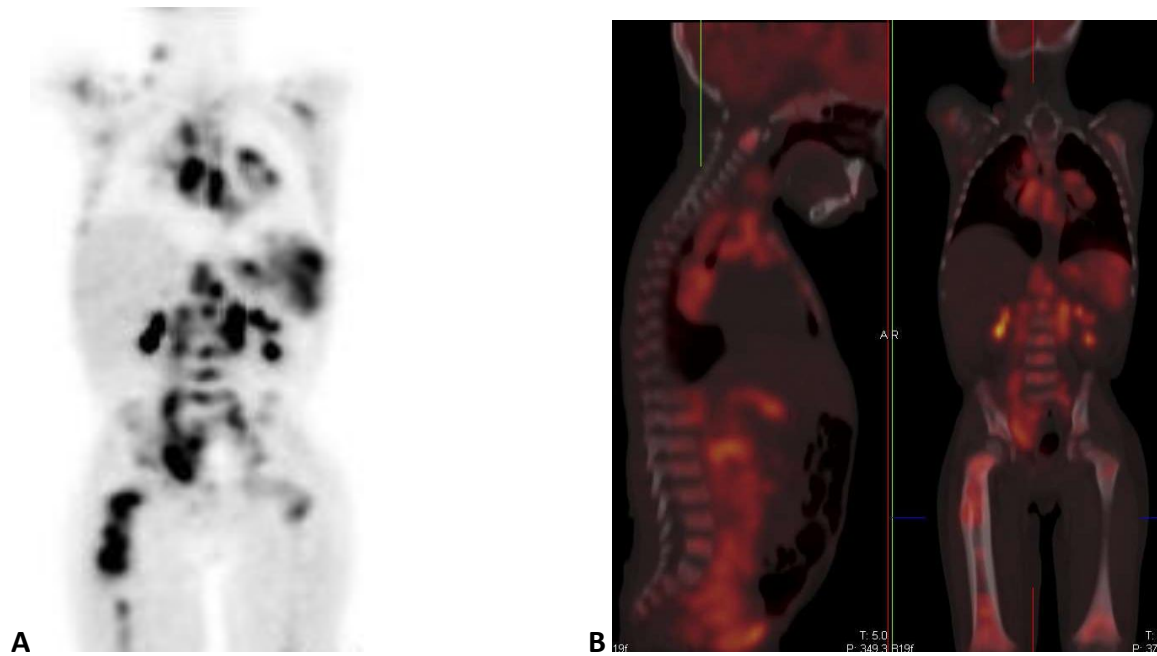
Patient C28, extensive bone marrow infiltration throughout the skeleton with CT bone changes in the right femur. Bone marrow infiltration was also found on BMB. A, coronal FDG PET image and B, sagittal and coronal FDG PET-CT images.
